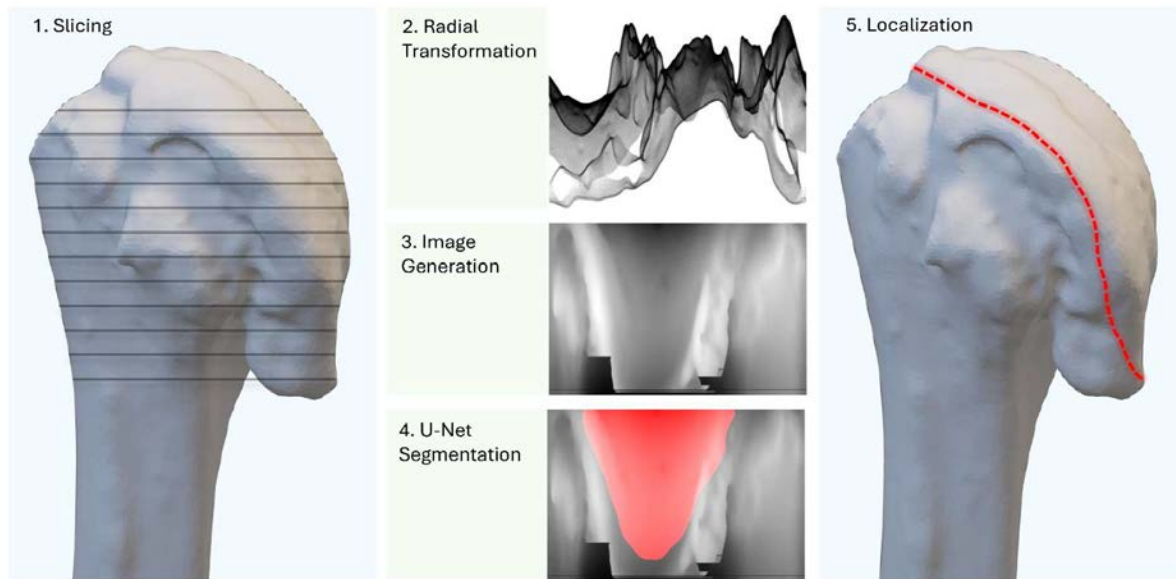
Topographic image compression for generating U-Net input images. 1) Segmented humerus CT is sliced. 2) Perimeter of each slice is transformed to radial coordinates. 3) Radial distance is normalized and stacked along z-height to form image. 4) Segmentation with U-Net 5) Boundary of segmentation transformed back to 3D
